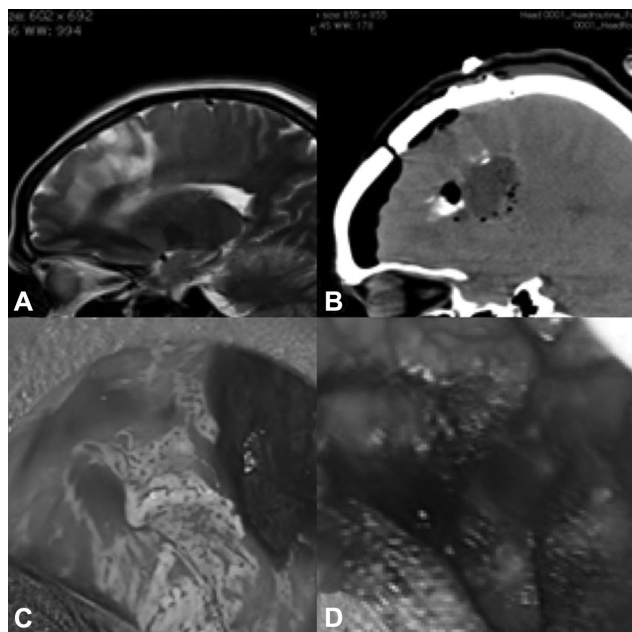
(A) T2 weighted sagittal image of the brain showing lesion in the left frontal lobe. (B) Sagittal computed tomography image showing postoperative changes in the left frontal lobe with small foci of air at the postoperative site and extra axial nondependent air in the frontal region. (C) Intraoperative endoscopic image showing tumor tissue. (D) Endoscopic view after tumor excision showing the surgical lining at the margins.
